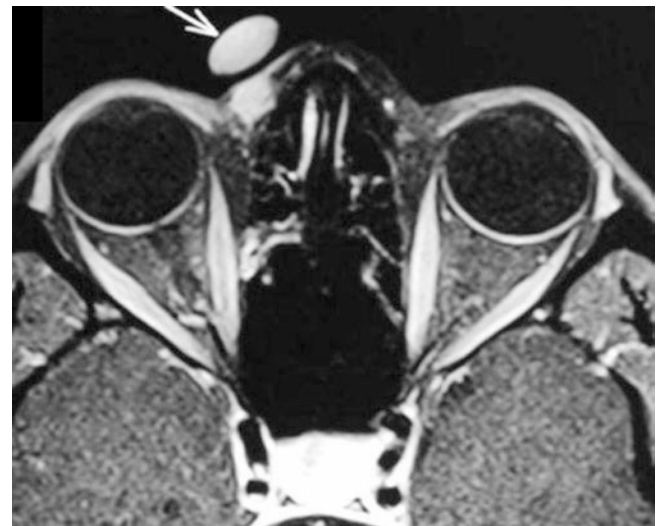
Axial T1w FS + contrast MRI image showing an avidly enhancing nodule at the medial canthus. A surface marker (vitamin E capsule) was placed over the region of interest (white arrow)
